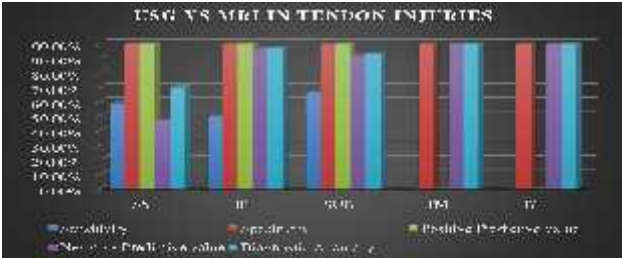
Validity of USG findings of tendon injuries for comparison to MRI findings.
